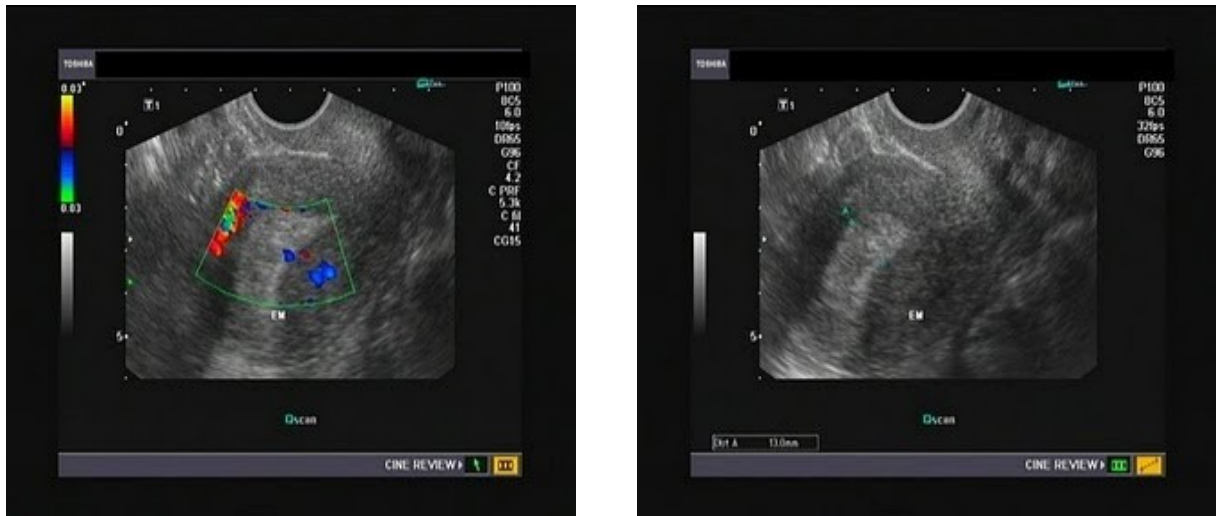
endometrial hyperplasia - (www.ultrasound-image.com)
